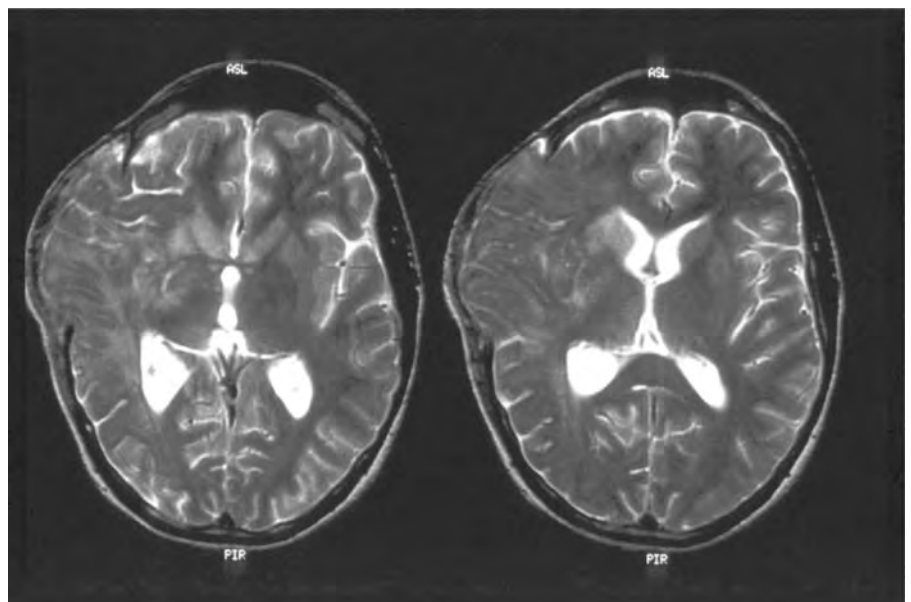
Malignant right hemisphere swelling relieved by surgical decompression following complete MCA territory infarction (MRI T2W).
